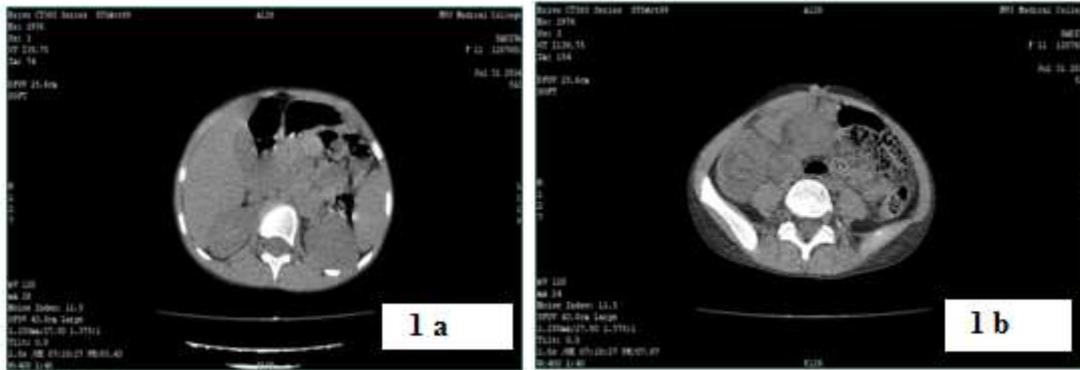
a and b: The selected axial sections of Non-contrast computed tomography abdomen and pelvis, showed a large cystic lesion with thick walls and a calcific focus within, in right iliac fossa extending into the pelvis and displaying the small bowel loop to the left
